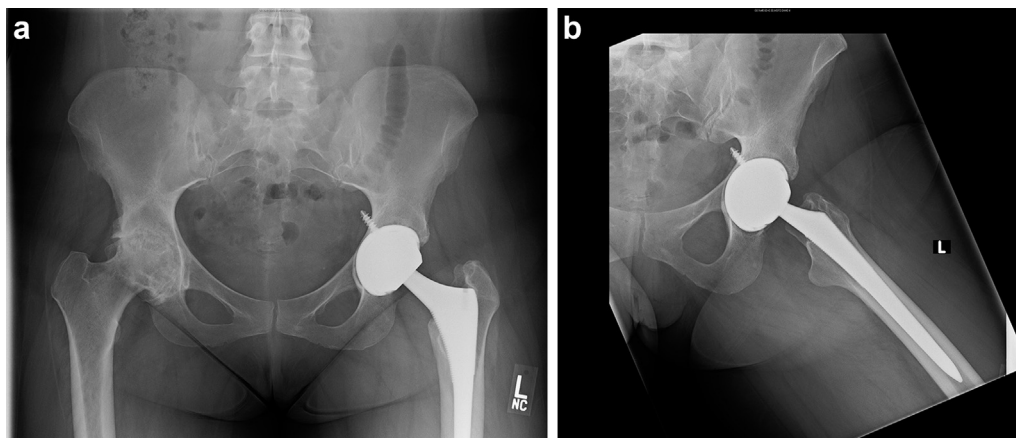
AP pelvis radiograph (a) and lateral view (b) of a 41-year-old woman with a hard-on-hard bearing surface combination demonstrating a complete radiolucent line surrounding the acetabular shell. The femoral stem appears to be well fixed.
